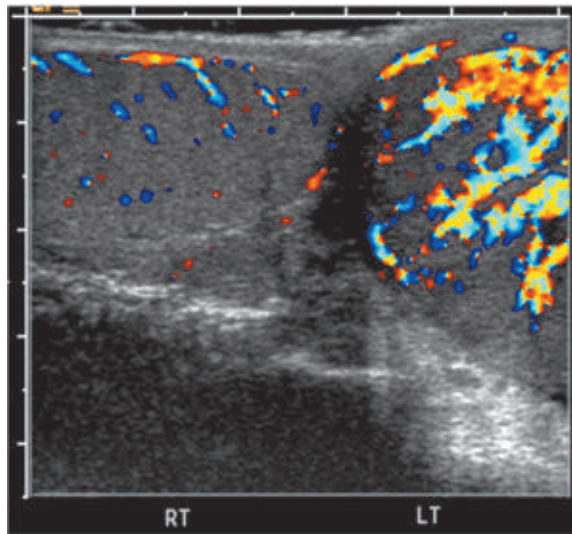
Doppler ultrasound examination of a testicular mass. Left testis (LT) shows an excess of blood vessels suggestive of testicular cancer. Blue indicates blood flowing toward and red indicates flow away from the transducer placed in contact with the scrotum.
